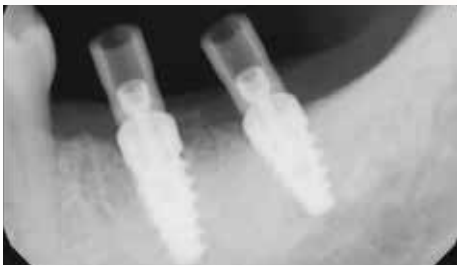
Scanning abutments designed for the Hahn Tapered Implant System were positioned, and a radiograph was used to verify complete seating.
